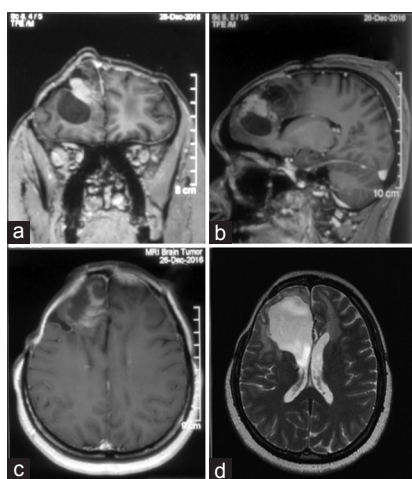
(a–c) Contrast-enhanced coronal, sagittal, and axial view of preoperative magnetic resonance imaging showing the tumor. (d) T2 axial image of the postoperative magnetic resonance imaging showing tumor excision
